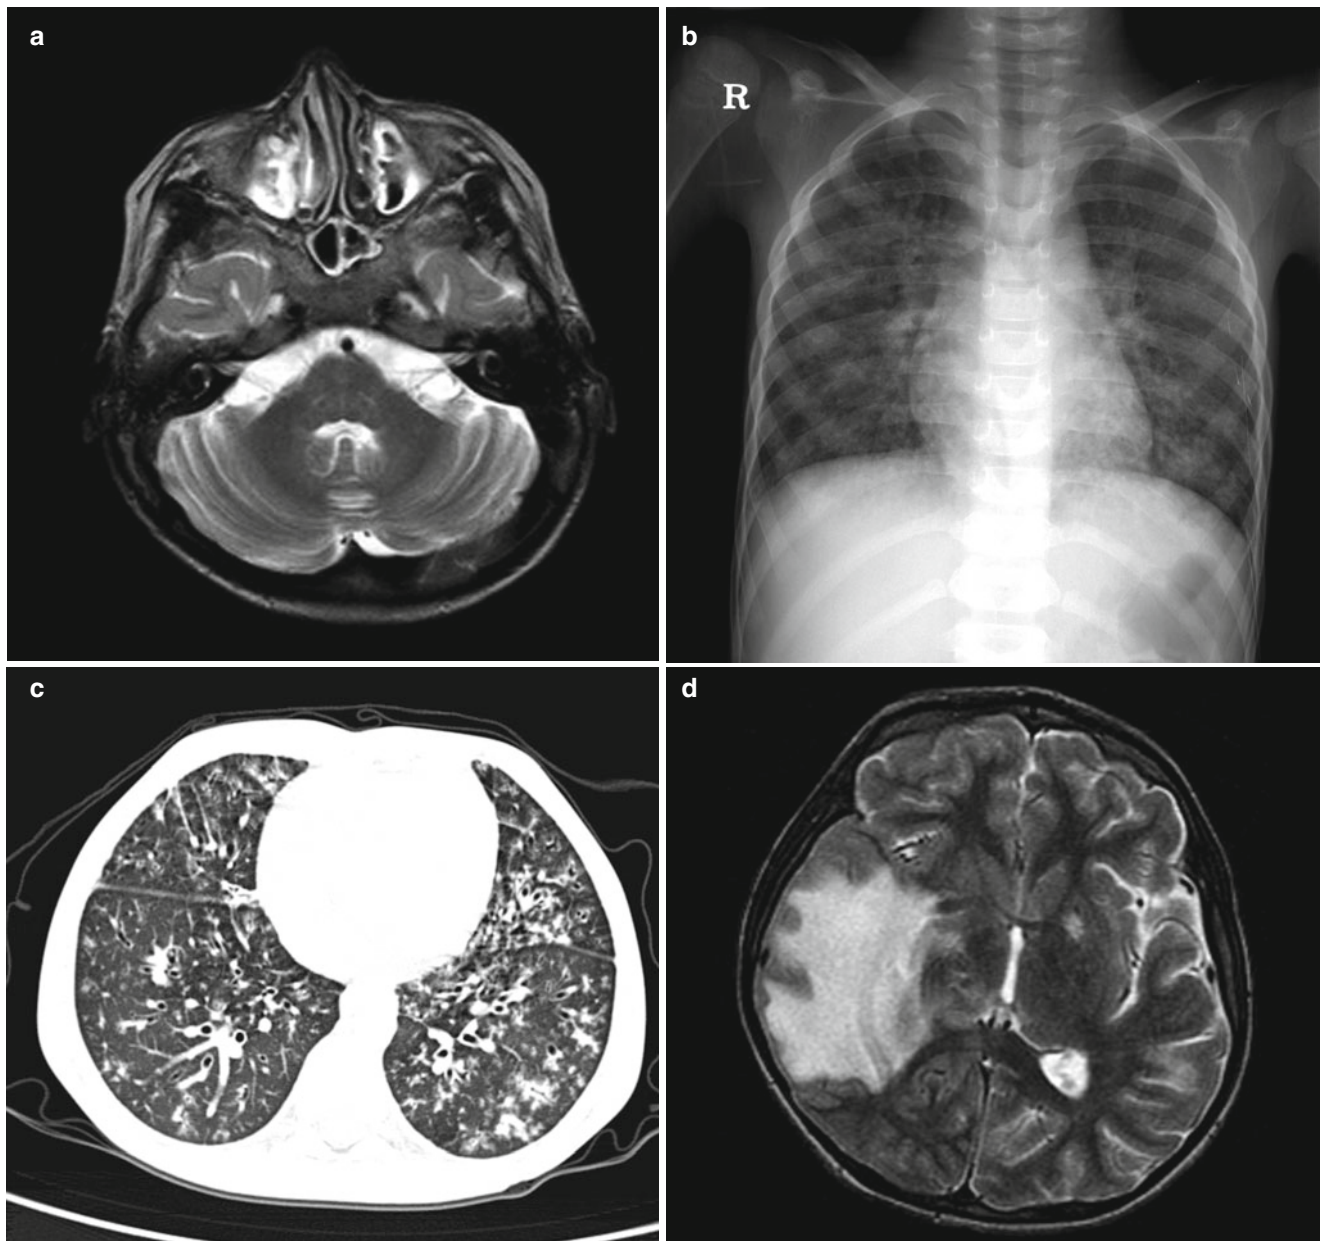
Ataxia-telangiectasia with recurrent respiratory infection. (a) T2 axial image shows prominent folia in the entire cerebellum. (b) Plain chest radiography shows diffuse nodular infiltrations in both lungs. (c) High-resolution CT of the lung shows disseminated
